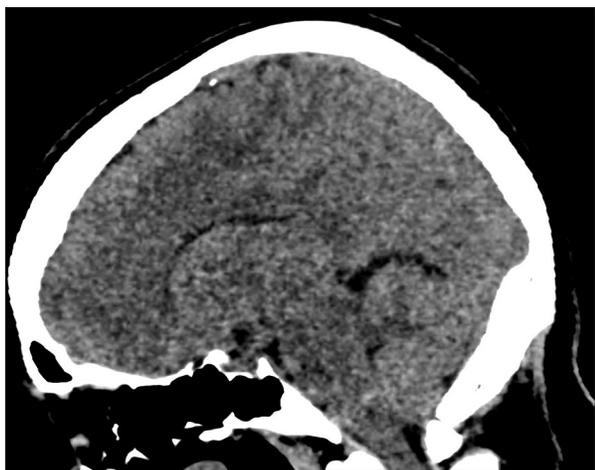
CT head (sagittal plane) showing sagging of brain
